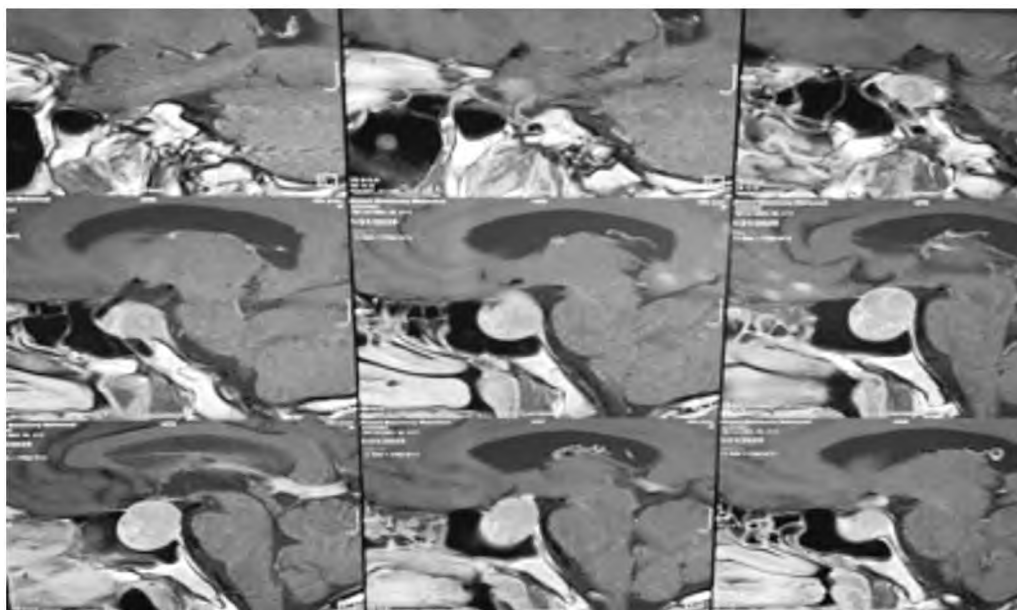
Pre-operative MRI sagittal cuts of one of the patient.
